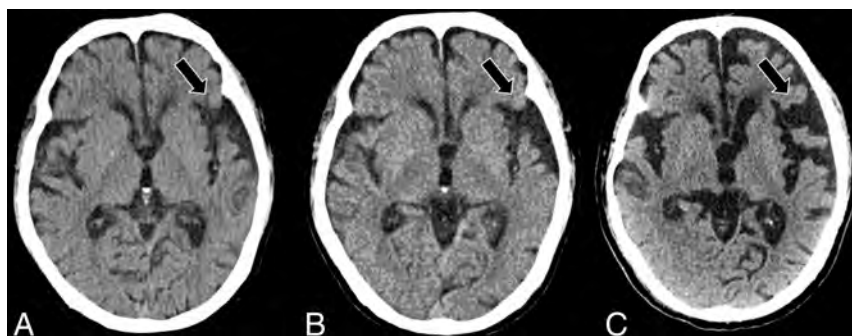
Serial axial CT scans at presentation (A), 2 years post-initial presentation (B), and 4 years post-initial presentation (C) in a right-handed individual with progressive language deficits demonstrate progressive widening of the left-greater-than-right Sylvian fissures (black arrows, A–C), suspicious for nfvPPA.
